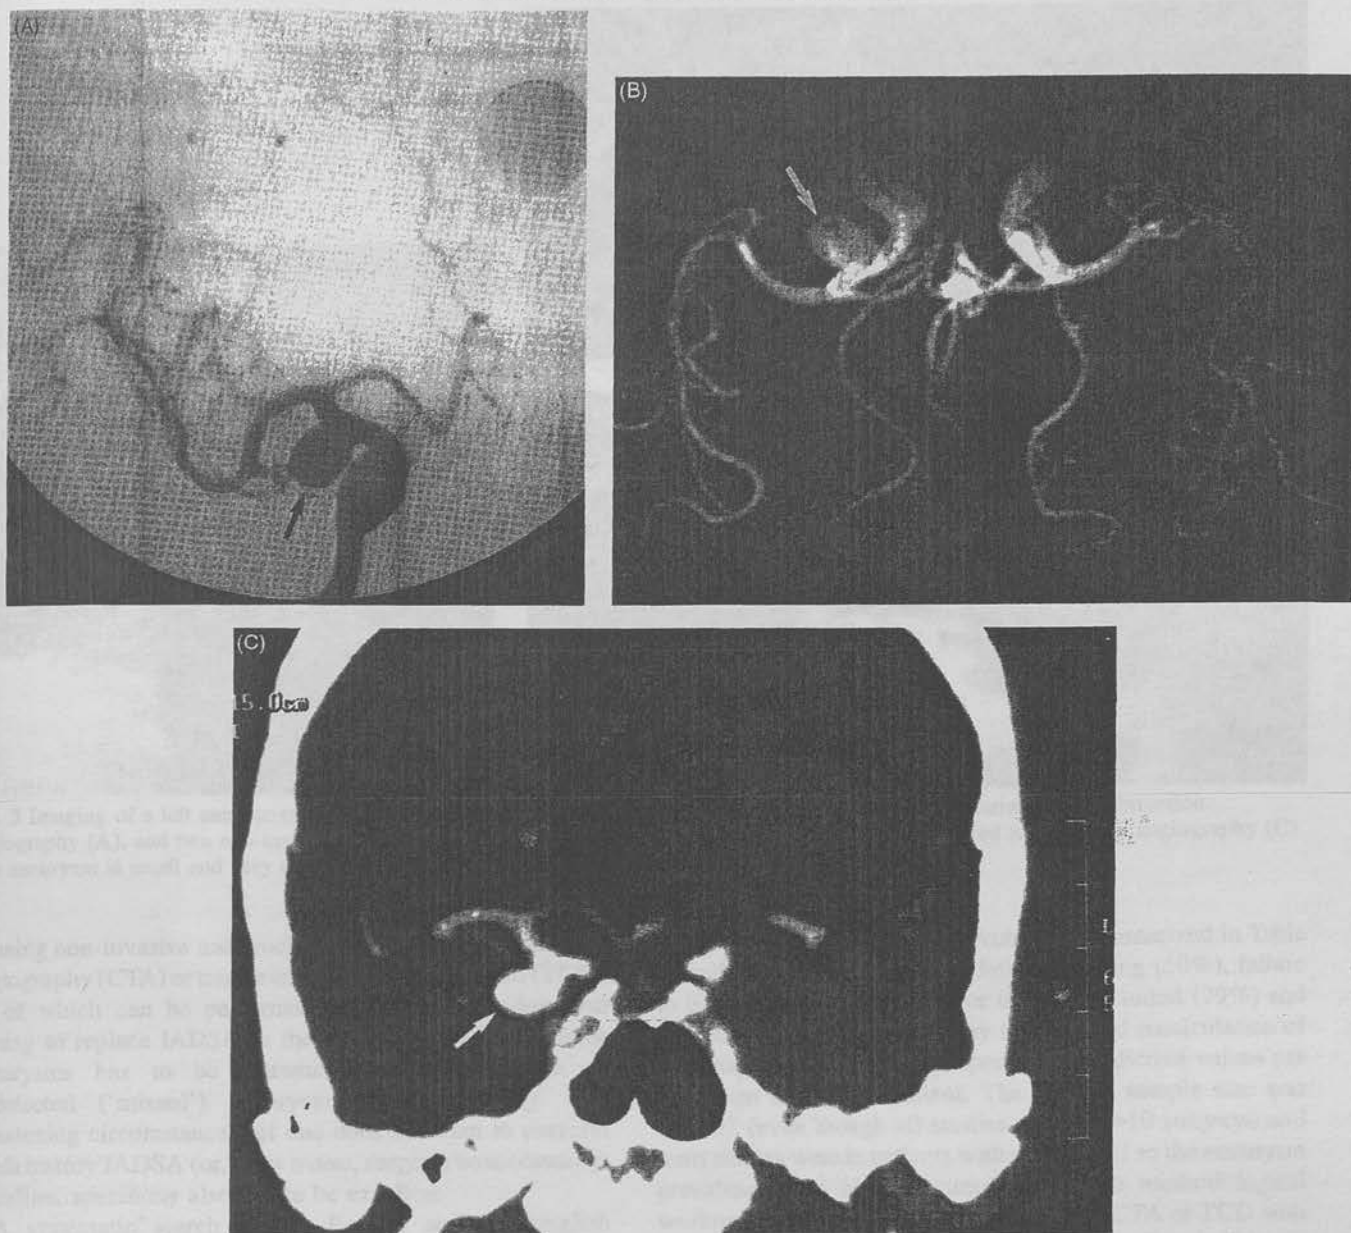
Imaging of a right posterior communicating artery aneurysm (arrow) with the gold standard intra-arterial digital subtraction angiography (A), and two non-invasive techniques, i.e. magnetic resonance angiography (B) and computed tomographic angiography (C). The aneurysm is large and readily identified by both non-invasive techniques.
